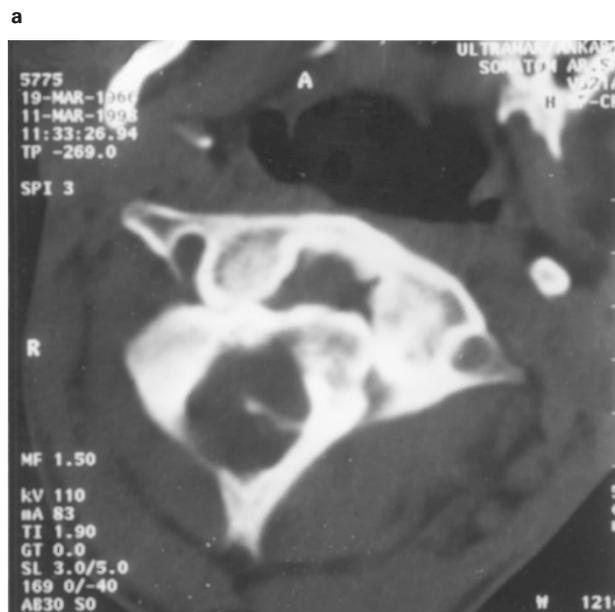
(A) Axial computed tomogram of the upper cervical spine demonstrates anterior sliding of atlas with a little rotation, and the dens unsatisfactorily visualized. (B) Lateral view of three-dimensional CT shows anterior sliding of atlas
